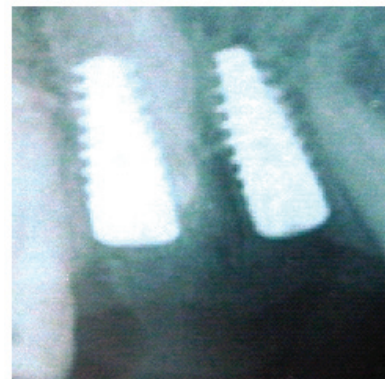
Intra Oral Periapical Radiograph after 3 months
